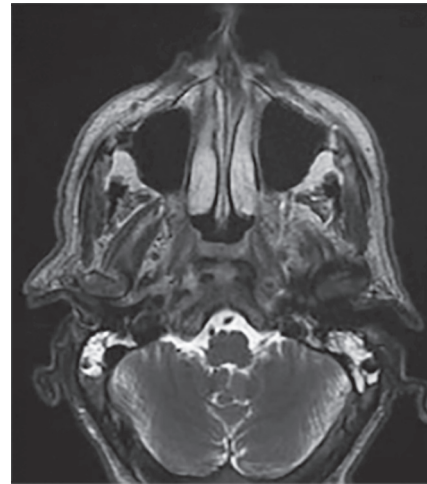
Magnetic resonance imaging (MRI) 2 sequence showing a hypointense sign of the nasopharyngeal lesion (characteristic of IPT)
